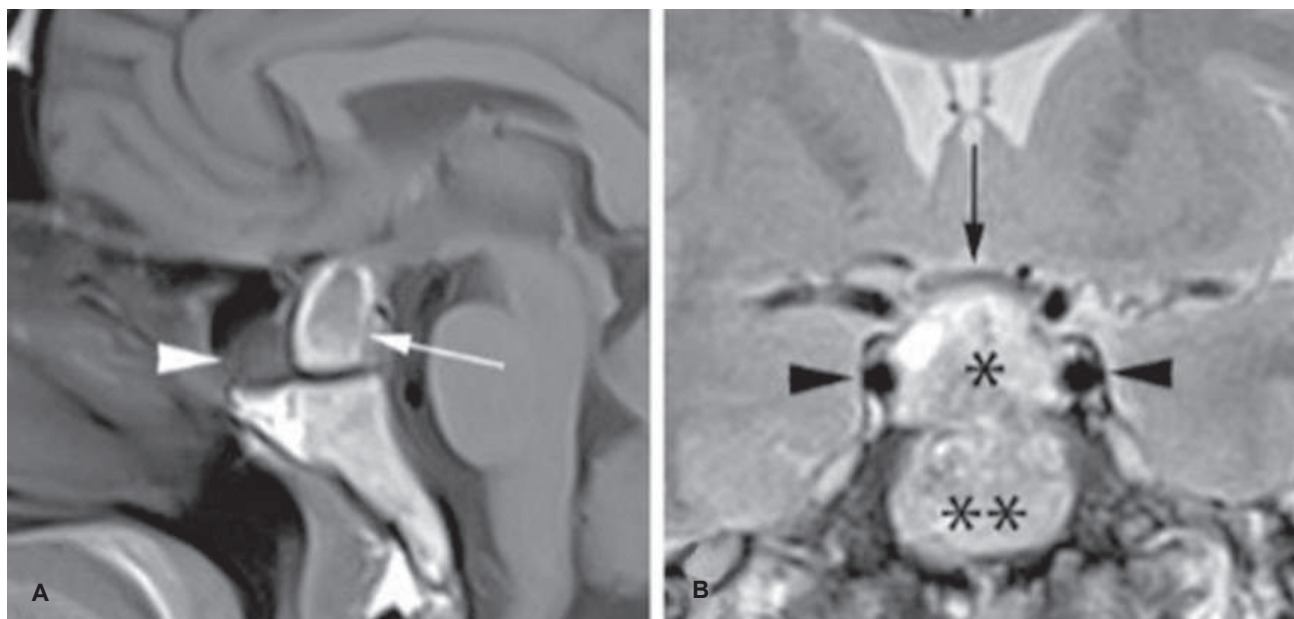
First pituitary MRI, T1-weighted midsagittal image without contrast (A) and T2-weighted coronal image (B). Heterogeneous pituitary mass but predominantly high signal at T2-weighted sequence (single asterisk in B). Its suprasellar component causes compression & mild upward displacement of the optic chiasm (black arrow in B). Double asterisks indicate the basisphenoid.
